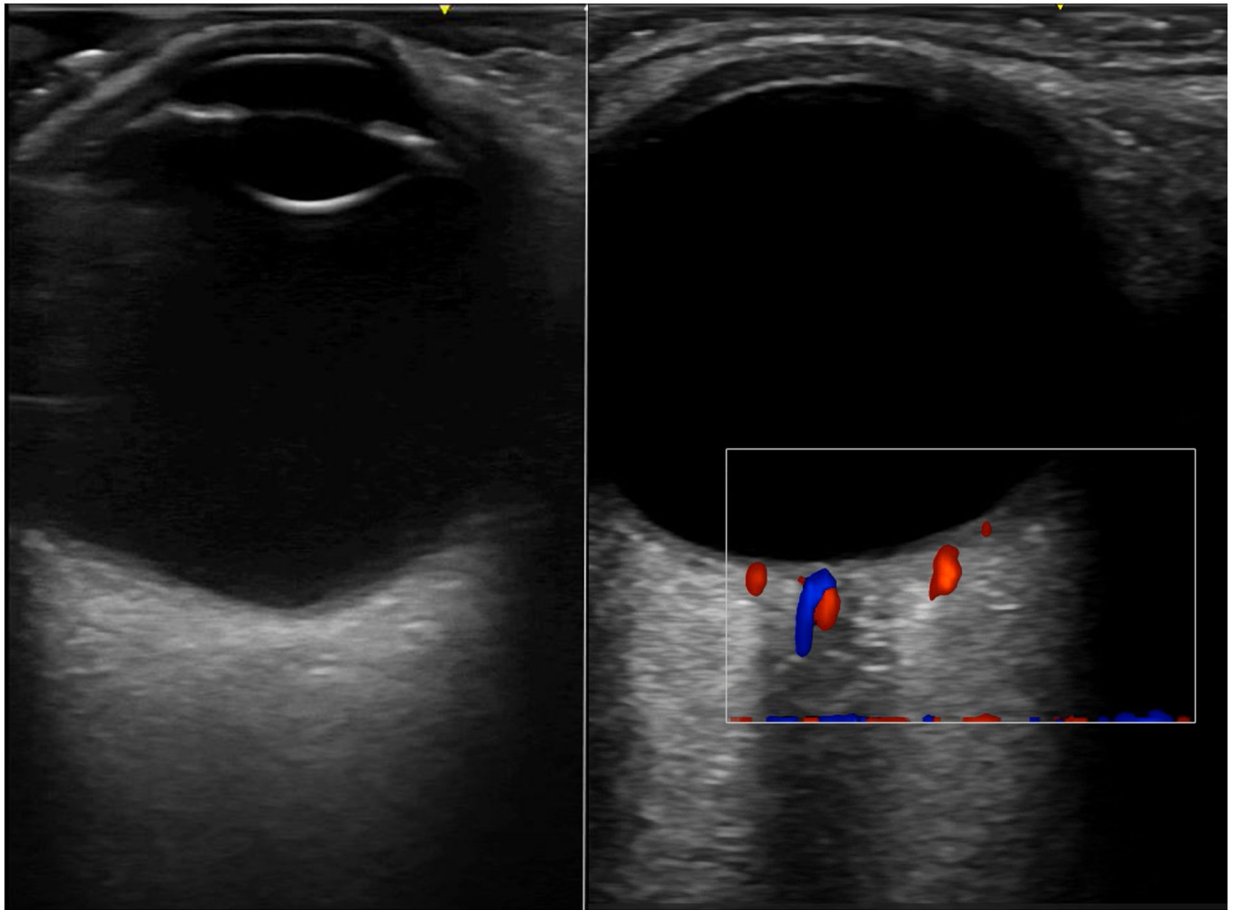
Axial B-scan and color-flow Doppler image obtained on GE Venue Go ultrasound system with L4–20t-RS linear array probe. The central retinal artery (red) and vein (blue) are visualized.
